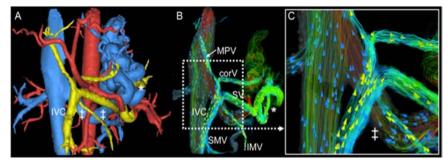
4D flow MRI can visualize and quantify alterations in blood flow, which can be dramatic in patients with portal hypertension. In this 59yo patient with cirrhosis, large porto-systemic collaterals (*) and shunting into an enlarged left renal vein (‡) are easily seen, as well as reversed flow in the splenic vein (SV) and coronary vein (corV), and diminished by hepatopedal flow in the main portal vein (MPV).
